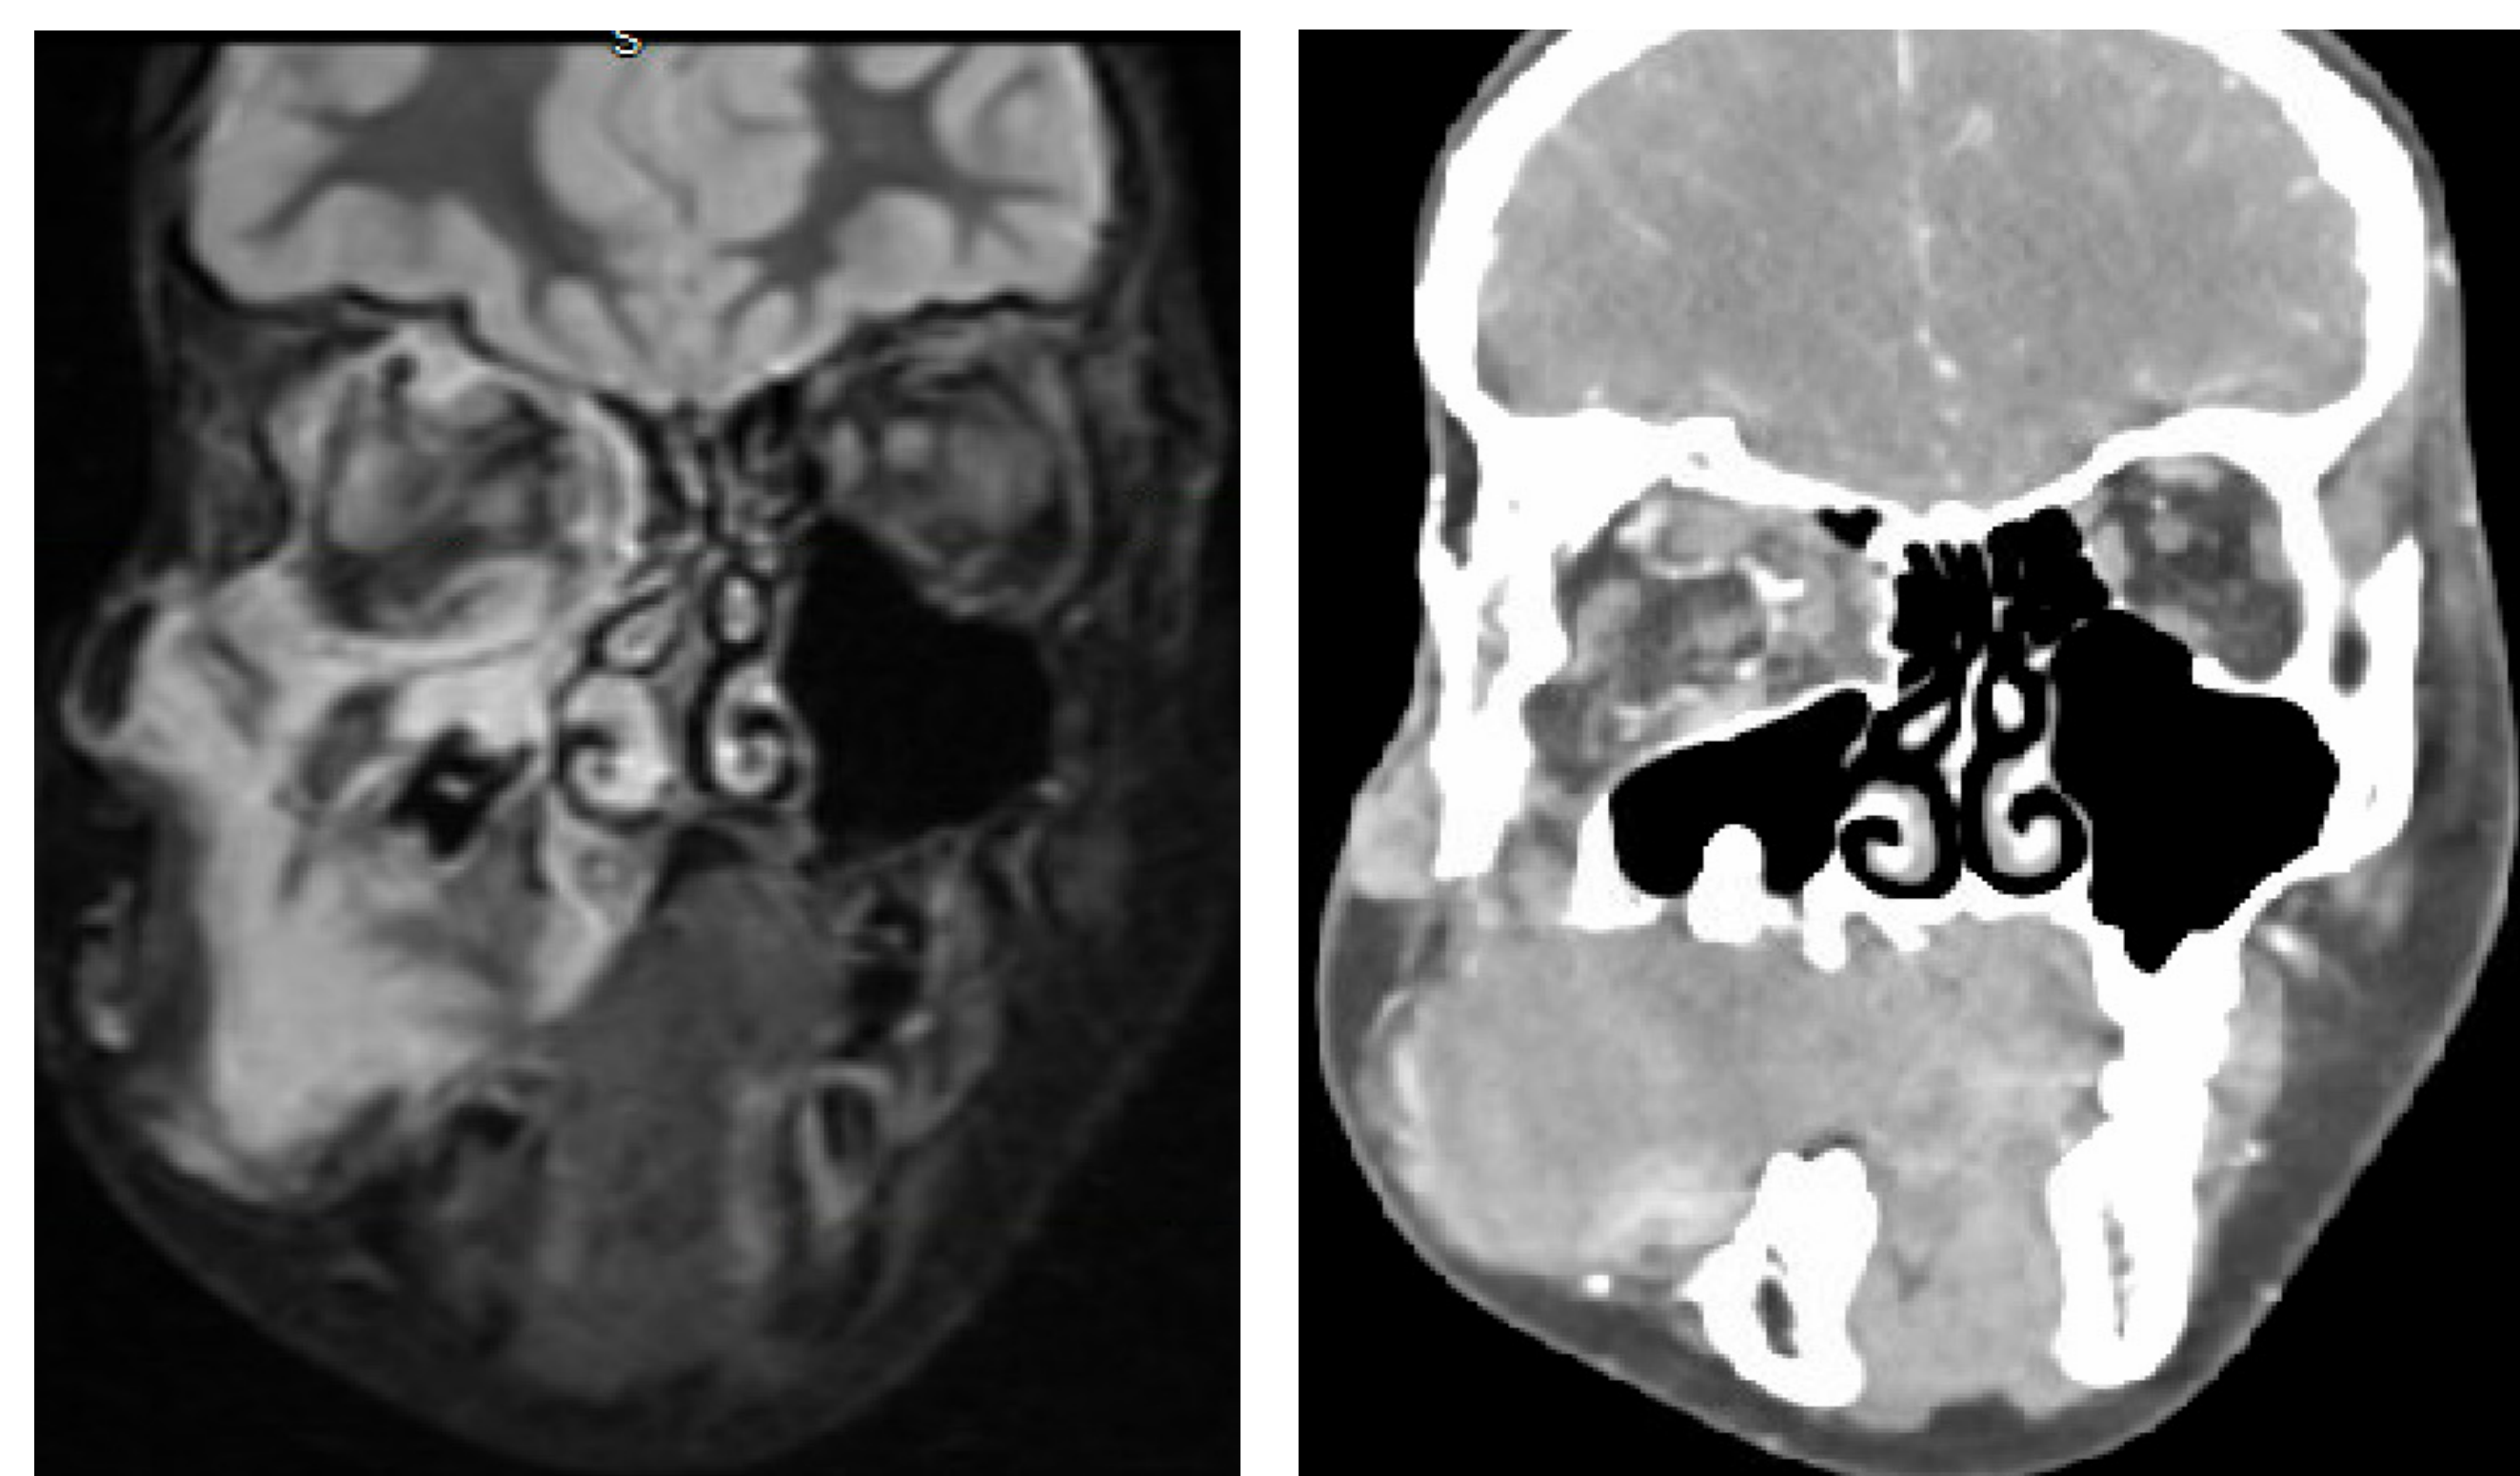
Coronal T1 MRI and CT images of large right facial plexiform neurofibroma.
